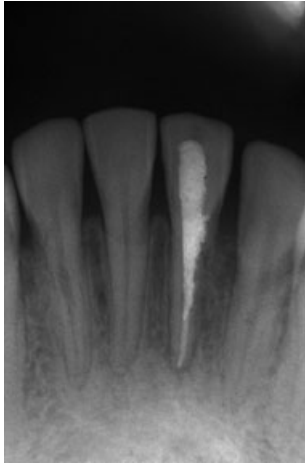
Radiograph taken 12 months after trauma. Resorption process of lower right second incisor is evident.
